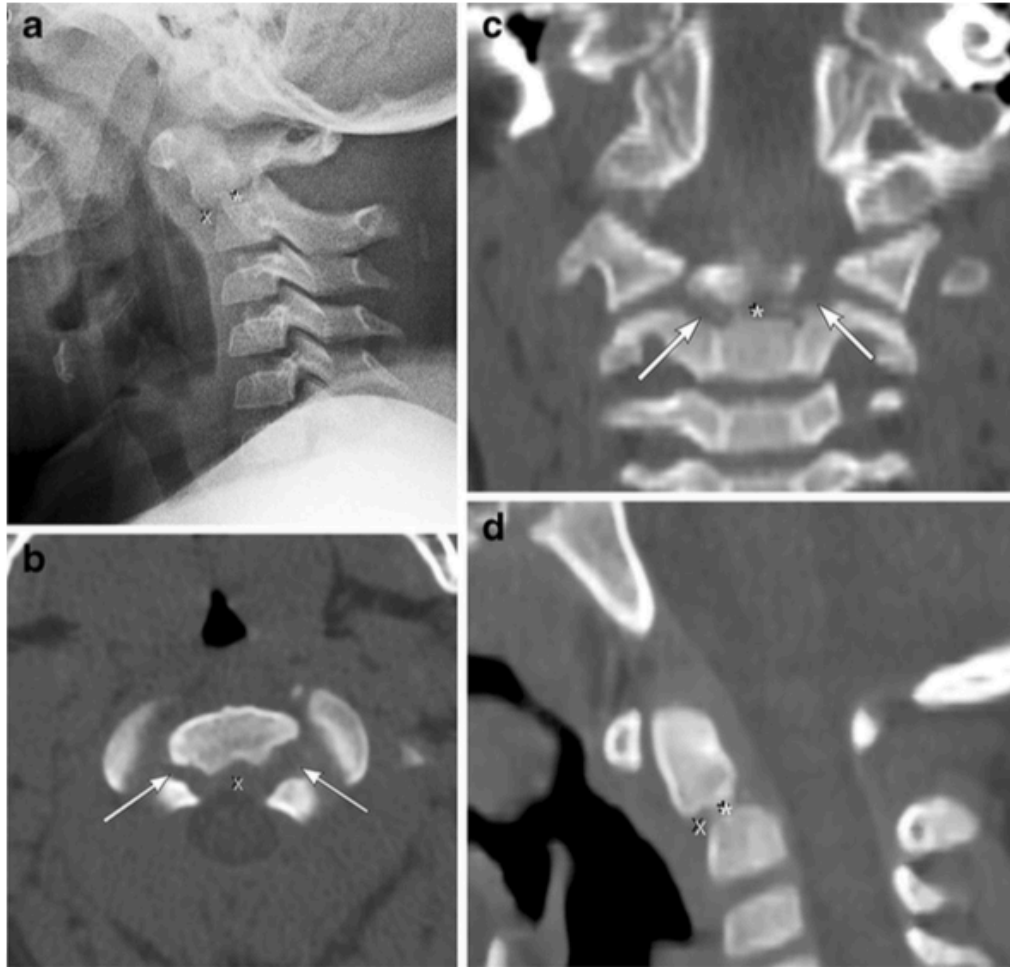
Type I subtype b fracture in patient 10, a 4-year-old boy with neck pain after motor vehicle crash. (a) Lateral radiograph, (b) axial CT, (c) coronal CT and (d) sagittal CT images show fractures of the right and left odontoneural (arrows) and the odontocentral synchondroses (*) with 3 mm anterior displacement (x), rotation and focal kyphosis (abnormal spine curvature). MRI showed localized edema (fluid collection) at C1-C2 as well as posterior soft tissue edema associated with T4 and T5 compression fractures (not shown). This boy also had a liver laceration (tear/cut) and lung contusion (bruising). The C2 fracture was successfully treated with halo stabilization.
